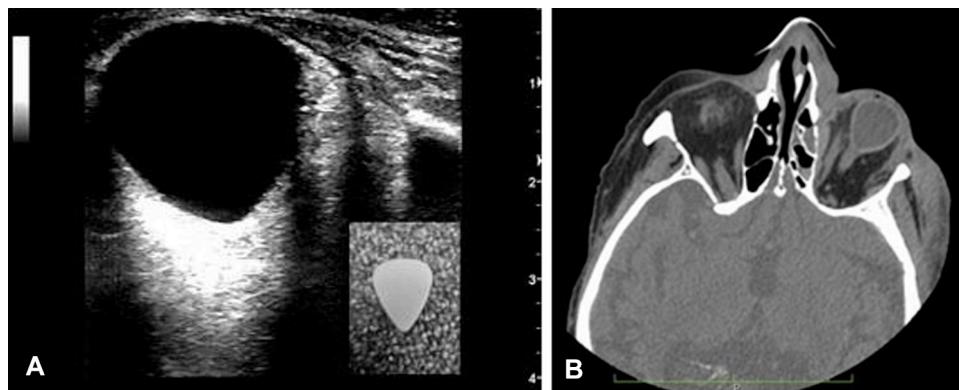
Guitar pick sign. A, Ultrasonographic image showing conical deformation of the left posterior ocular globe, mimicking the shape of a guitar pick. B, Computed tomography scan of the orbits demonstrating conical deformation of the left posterior ocular globe. Reproduced with permission from Theoret et al.¹¹⁷
